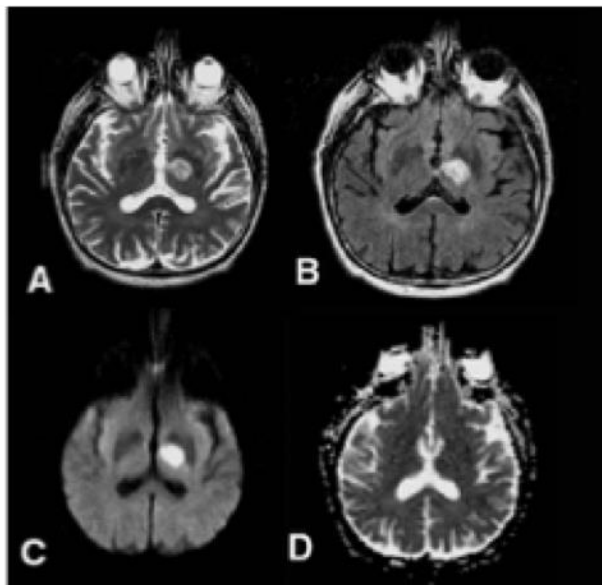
T2 shine-through effect. A) hyperintense lesion in the left hemisphere on T2-W image; B) also appears bright on the FLAIR image; C) appears bright on DWI while no changes appear on D) ADC map. reprinted from Diffusion-weighted imaging: Basic concepts and application in cerebral stroke and head trauma. *Eur Radiol.* 2003;13(10):2283-2297. doi:10.1007/s00330-003-1843-6.
